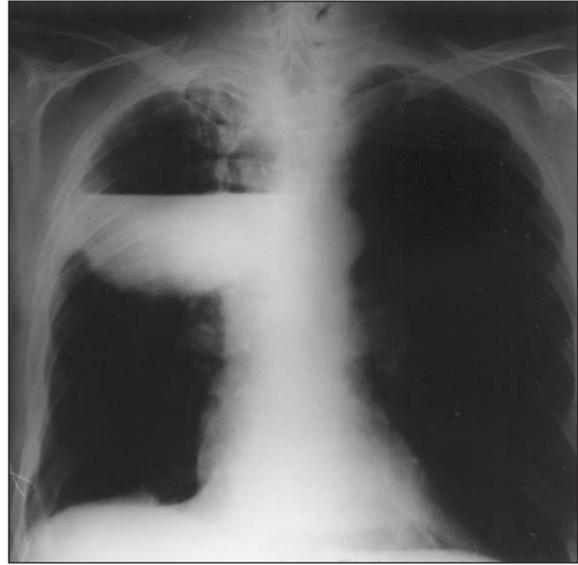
Chest radiography revealing abscess formation.
